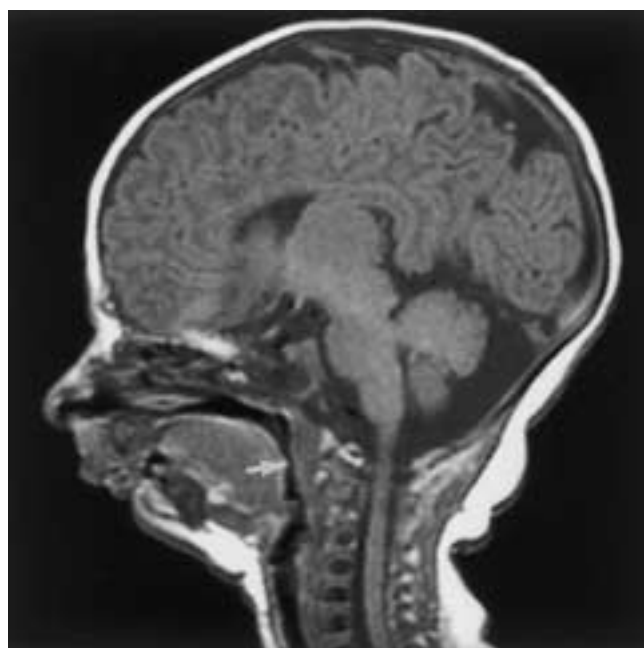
Prader-Willi syndrome in a young child with obstructive sleep apnea. Sagittal T1-weighted MR image shows micro- and retrognathia. The posterior displacement of the tongue and narrowed AP diameter of the airway (*arrow*) are well seen on MR imaging.
